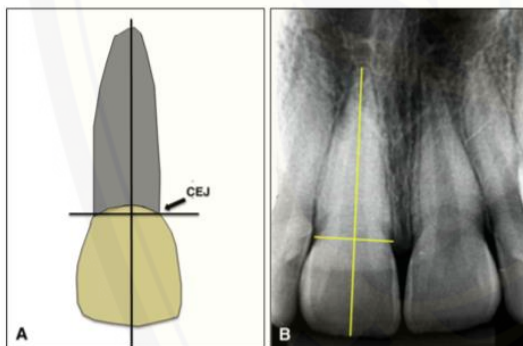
A) Anatomic landmarks for measuring EARR: cementoamel junction (CEJ). B) A reference for measuring X-rays.¹²
